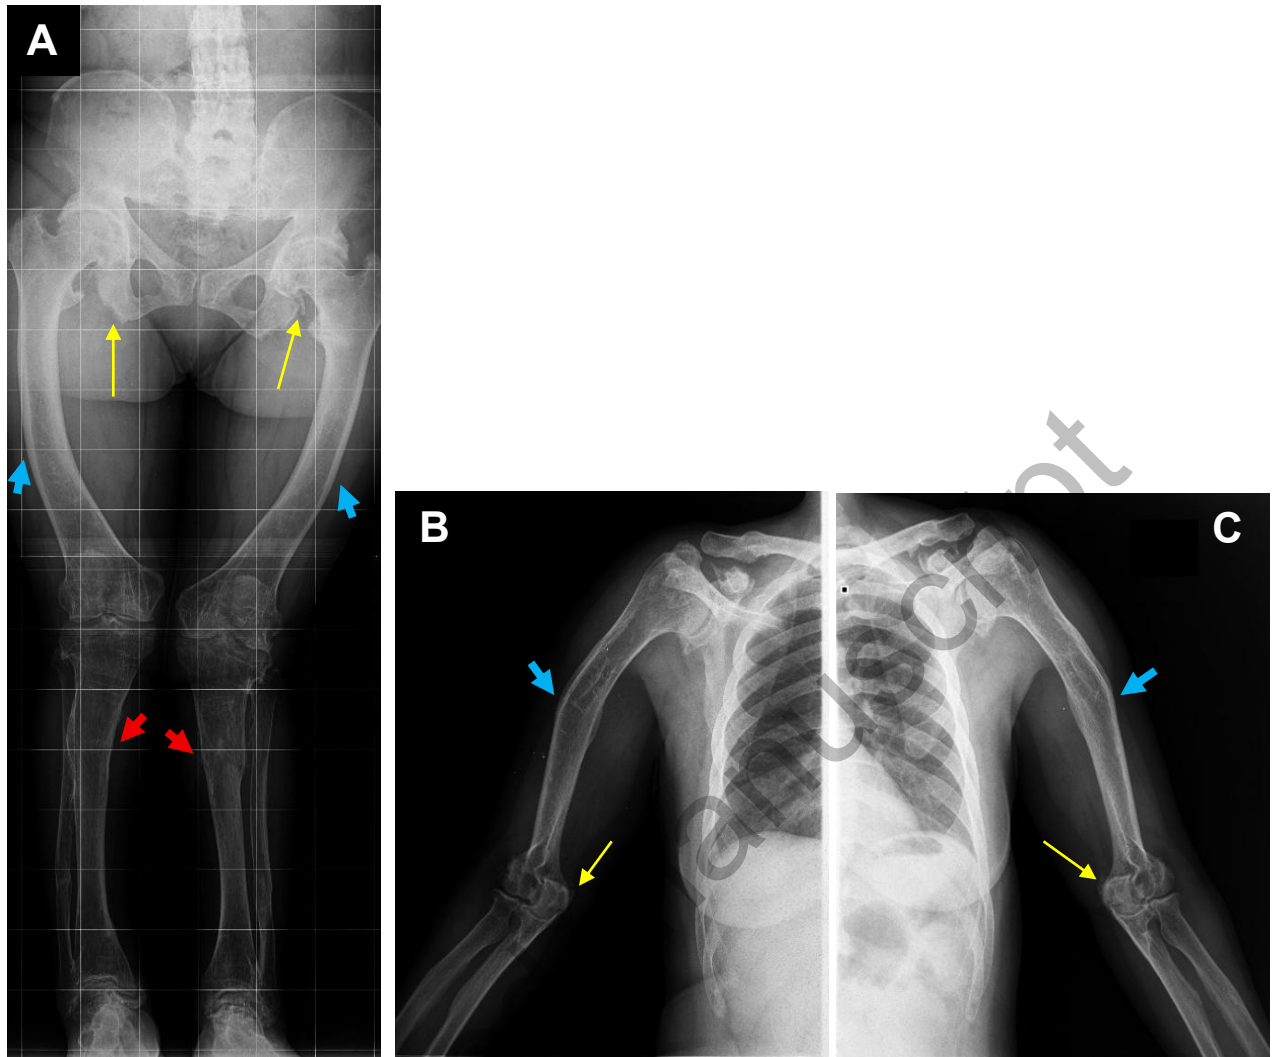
Radiographic features of long bone deformities in the reported patient.
